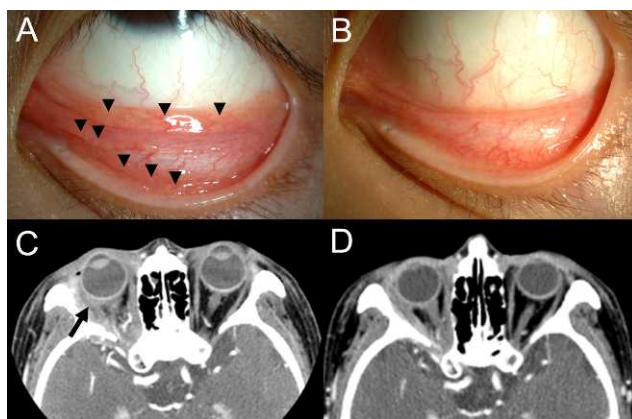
Representative cases with ocular adnexal MALT lymphoma showing response to doxycycline treatment. (A) and (B) Case 1. Left conjunctival MALT lymphoma case. (A) Pinkish masses on forniceal and tarsal conjunctiva (arrow heads) revealing ocular adnexal mucosa-associated lymphoid tissue (MALT) lymphoma. (B) Five months after double course of doxycycline treatment, masses were completely regressed. (C) and (D) Case 2. Right orbital MALT lymphoma case. (C) Contrast-enhanced CT scans showing well-enhancing, diffuse orbital mass (arrow). (D) The mass was much decreased 7 months after double-course doxycycline treatment.
